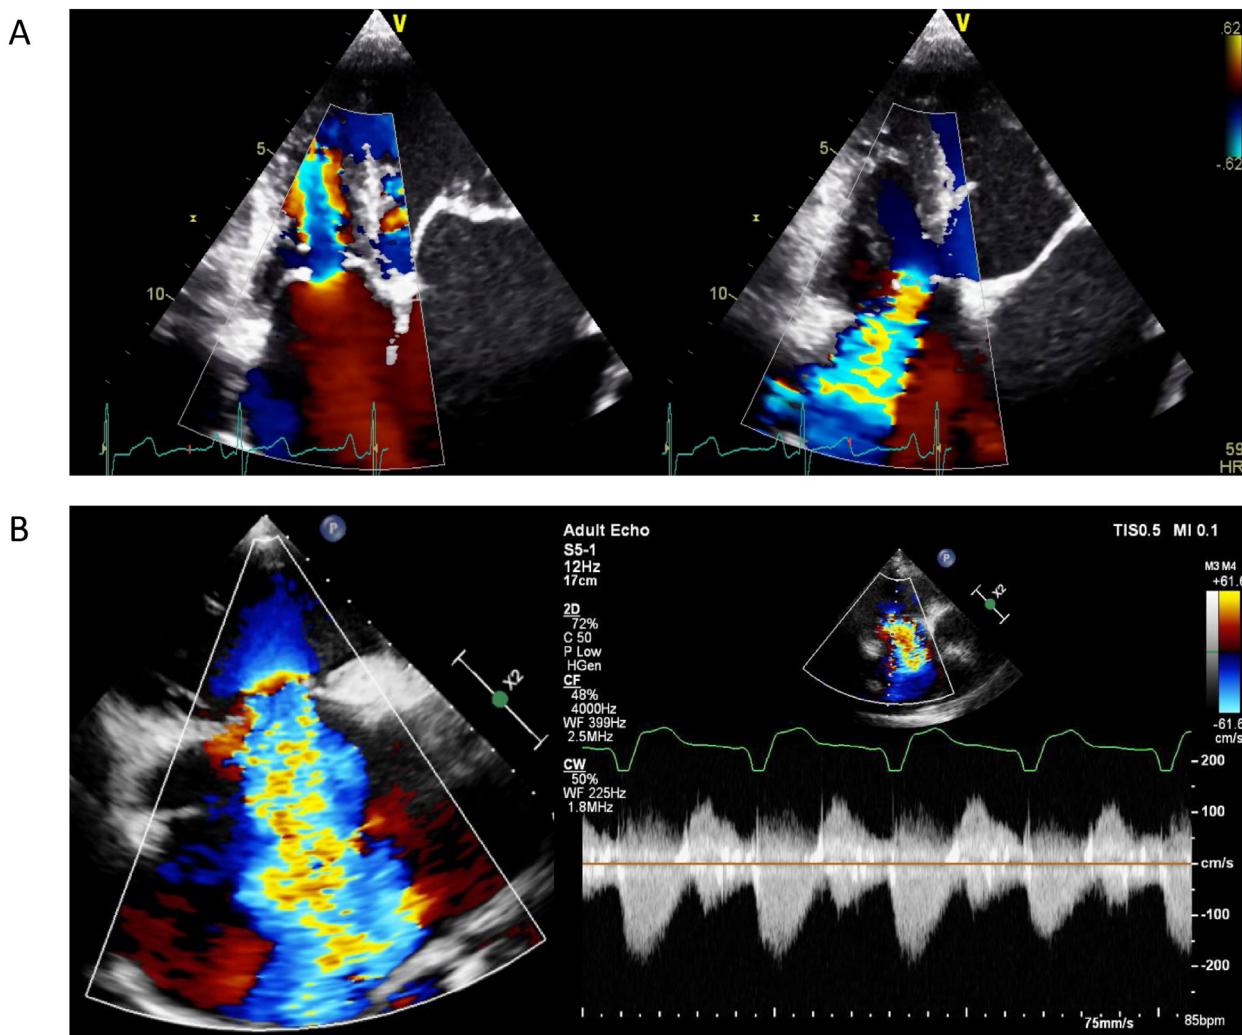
Rheumatic TR. (A) Left, Apical 4-chamber view of TV with color Doppler in diastole; Right, Apical 4-chamber view of TV with color Doppler in systole. *Figure courtesy of Dr. Manish Bansal, New Delhi, India.* (B) Severe TR with a large color Doppler regurgitant jet area, a wide VC ≥ 0.7 cm, and a dense triangulated continuous-wave Doppler flow profile with low velocity (<2 m/sec), indicating rapidly rising right atrial pressure due to severe TR.
